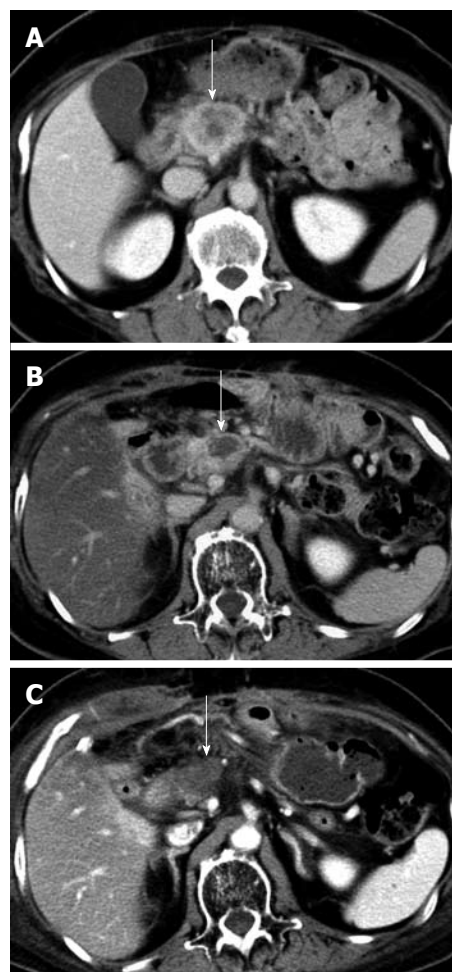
Abdominal contrast-enhanced computed tomography scan. A: contrast-enhanced computed tomography (CE-CT) scan showing a tumor in the pancreatic head before the first laparotomy (arrow); B: CE-CT scan taken after the chemoradiotherapy showing a reduction in the size of the tumor (arrow); C: CE-CT scan taken after the radiofrequency ablation showing a necrotic area that is suggestive of an ablated tumor (arrow).
